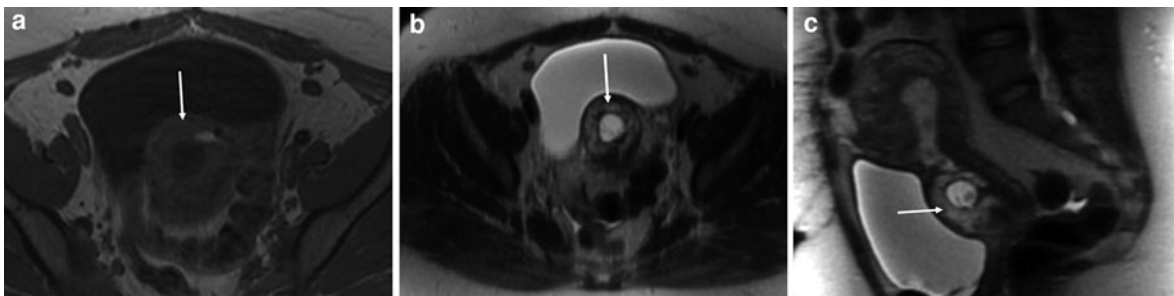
Ectopic pregnancy in a 40-year-old pregnant woman. Axial T1-weighted gradient-echo image (a) shows a well-defined, hypointense, cystic structure (arrow) at the anterior-inferior aspect of the uterus. Axial T2-weighted single-shot fast spin-echo image (b) reveals the ectopic positioning gestational
